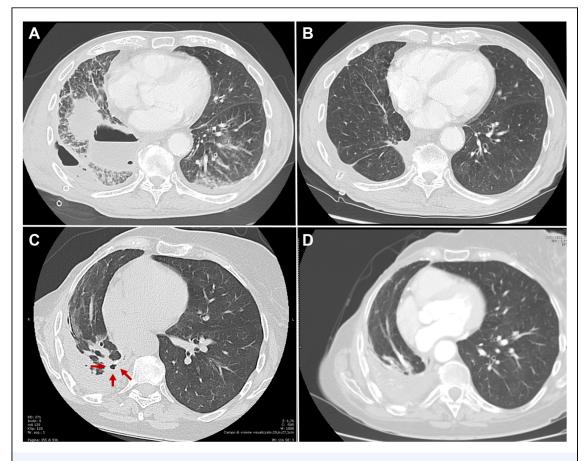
(Top) Computed tomography (CT) scan of patient 1. (A) CT scan showing large right hydropneumothorax owing to bronchopleural fistula in the bronchial stump of right lower lobectomy. A chest drainage was placed in the intrathoracic collection. (B) CT scan 2 weeks after endoscopic treatment showing resolution of hydropneumothorax. (Bottom) CT scan of patient 2. (C) CT scan showing bronchopleural fistula (red arrow) in the bronchial stump of right lower lobectomy. (D) CT scan 2 months after endoscopic treatment showing persistent closure of the fistula.
